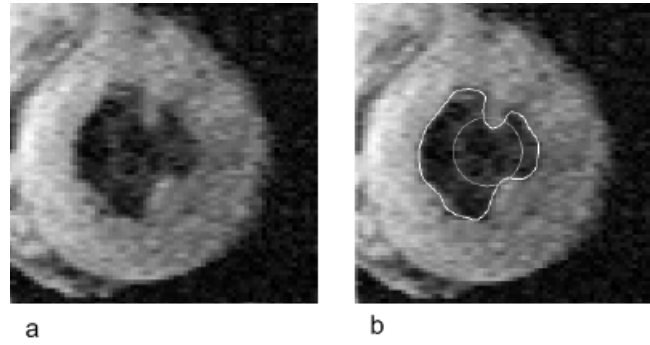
The segmentation of the left ventricle from an MRI study using an active contour model. a) The original image. b) The initial placement of the circle within the left ventricle and the final result after deformation of the circle. From Pham et al. (2000).
